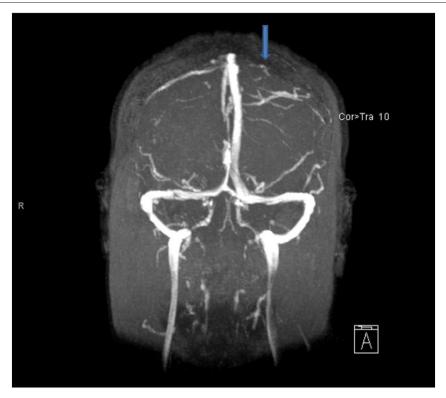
Magnetic resonance image demonstrating a left superficial cortical vein thrombosis (arrow).
